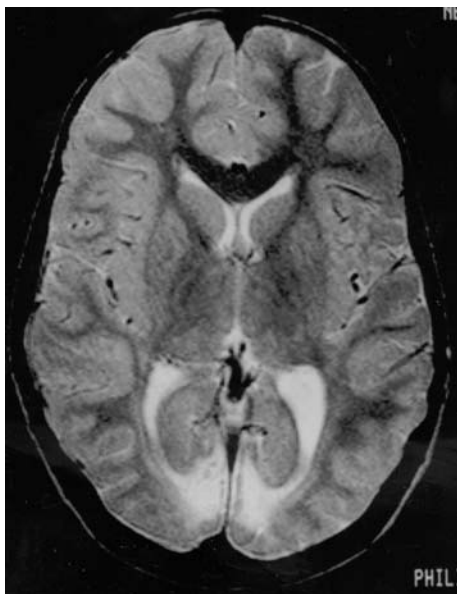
Axial T2-weighted MRI of a 6-year-old girl with moderate mental retardation, spastic cerebral palsy, visual impairment. History of prolonged seizures at 3 months. MRI shows bilateral focal signal alteration in the medial occipital cortical/subcortical areas. The exact pathogenesis remains speculative (seizure related)
